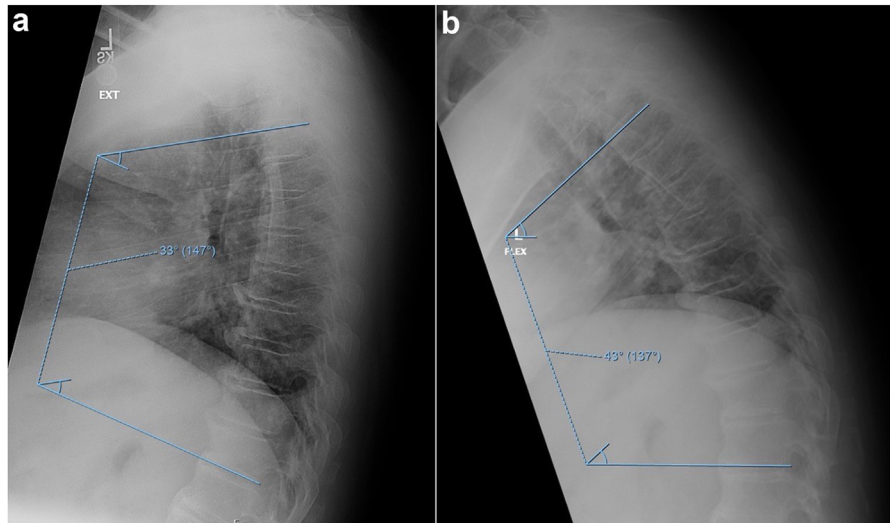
Functional radiographs of the thoracic spine in extension (a) and flexion (b) more than 1 year after THA: Thoracic kyphosis increased from 33 degrees to 43 degrees from extension to flexion.
